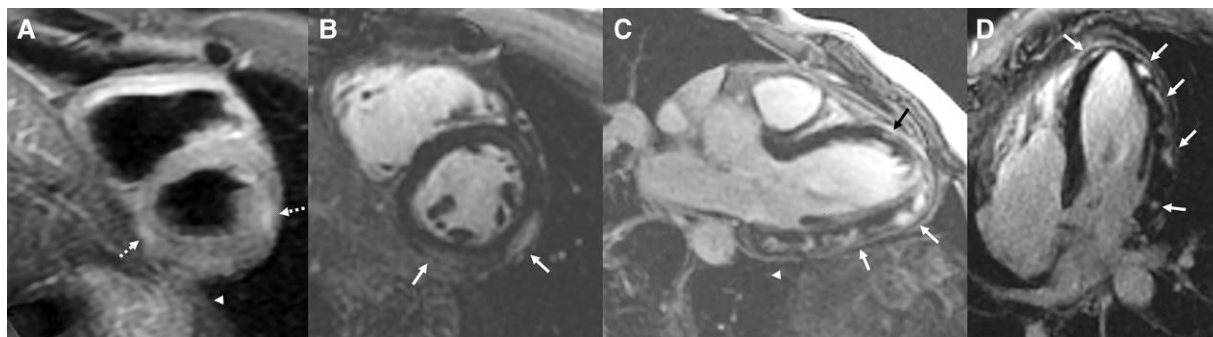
Cardiac magnetic resonance imaging performed 4 days after his admission demonstrating imaging features consistent with myocarditis for Patient 1. Late Gadolinium enhancement of left ventricular mass = 22%. (A) Short-axis oblique T₂-weighted image demonstrating epicardial hyper-intense signal in the lateral and inferior wall (dotted arrows). (B) Short-axis oblique late gadolinium enhancement demonstrating epicardial hyper-intense signal in the lateral and inferior wall (white arrows). (C) Four-chamber late gadolinium enhancement demonstrating epicardial hyper-intense signal in the lateral and apical wall (white arrows). (D) Three-chamber view late gadolinium enhancement demonstrating epicardial hyper-intense signal in the lateral and apical wall (white arrows).
